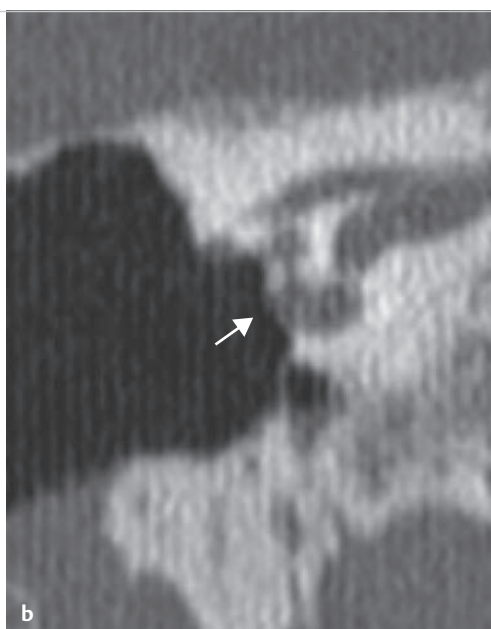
The postoperative axial CT demonstrates large fistula in the lateral semicircular canal (a) and coronal CT in the basal turn of the cochlea (b, arrow). Note the clean cavity demonstrated in both slices.
